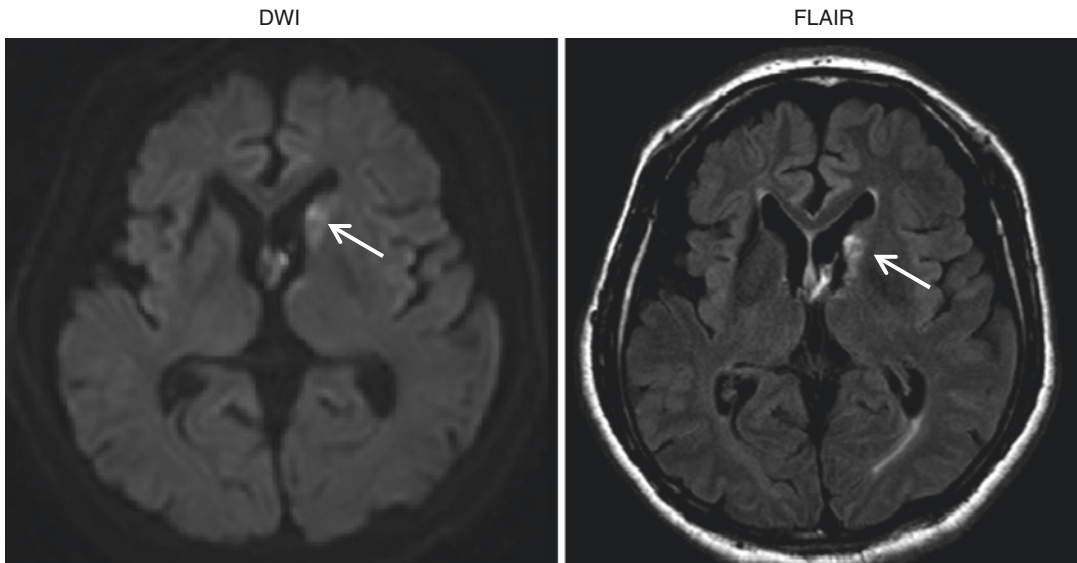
MR images in patients with single strategic infarct dementia. DWI (left) and FLAIR (right) images show left caudate infarction (white arrow) in a 67-year-old man who developed memory impairment and abulia
